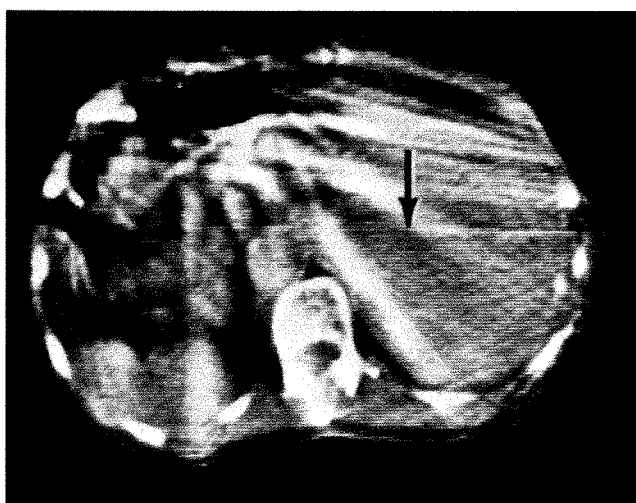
CT biopsy of liver neoplasm. Arrow points to tip of needle placed within mass. Biopsy positive for hepatocellular carcinoma.
